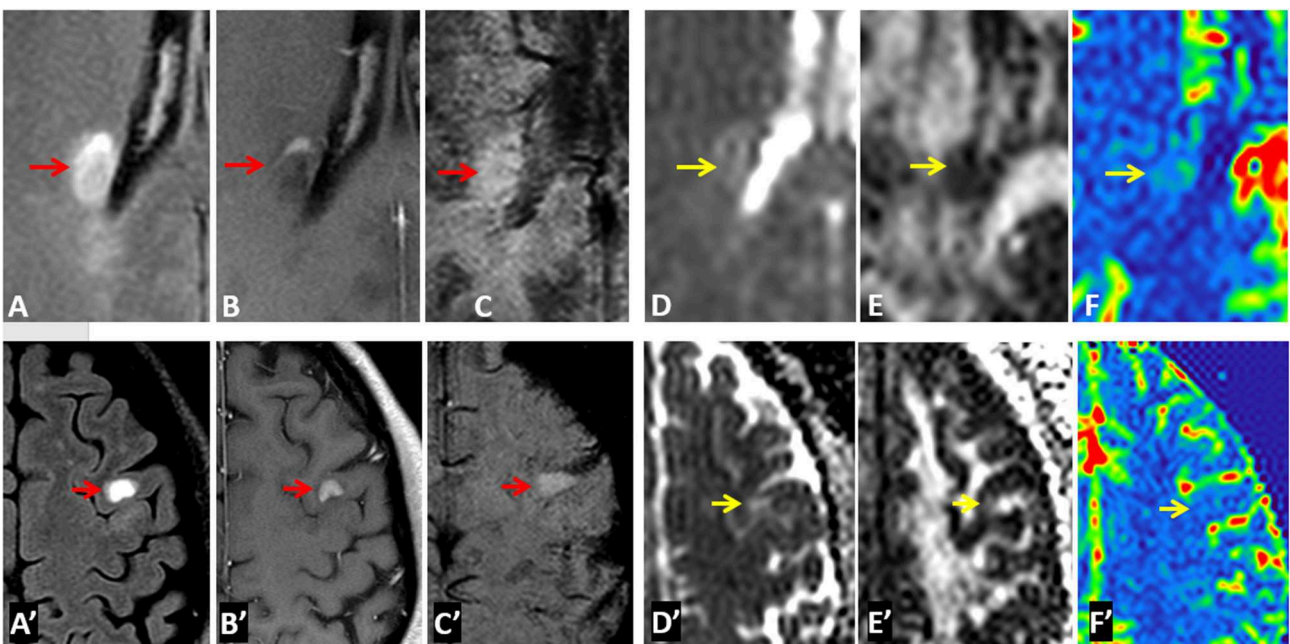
Representative images of Type-3 lesions in two MS patients (top row from a 32-year-old female and bottom row from 41-year-old female patient) include FLAIR (A,A'), Gd-enhanced T1-weighted (B,B'), SWI (C,C'), as well as parametric maps of MD (D,D'), FA (E,E'), and CBF (F,F'). The hyperintense lesions (arrow) on SWI showed gadolinium enhancement that is corresponding to increased perfusion and slightly increased MD as well as decreased FA.
